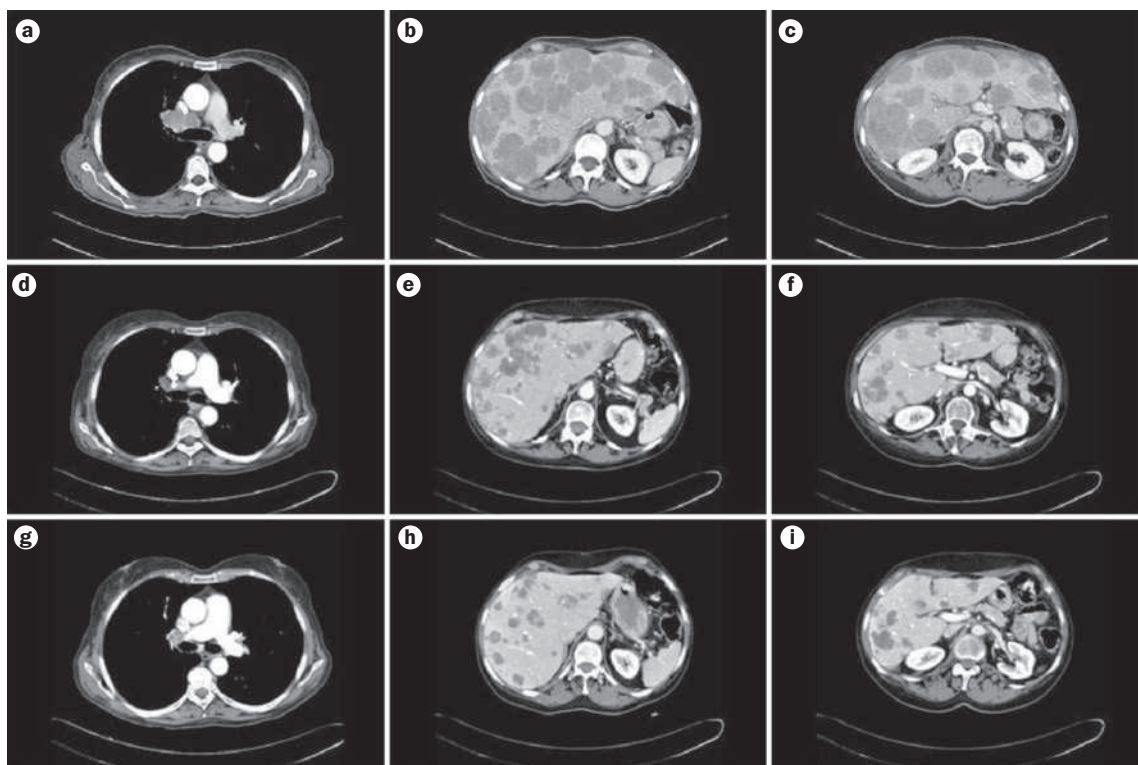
CT scan images taken at baseline, after 4 cycles of chemotherapy and after cessation of this treatment. Images demonstrate the considerable reduction in dimensions and numbers of mediastinal and hepatic lesions from baseline (a–c) observed after four cycles (d–f) of combination chemotherapy with liposomal doxorubicin and capecitabine. Images g–i were taken 4 months after the end of chemotherapy, while the patient was receiving single-agent octreotide.
